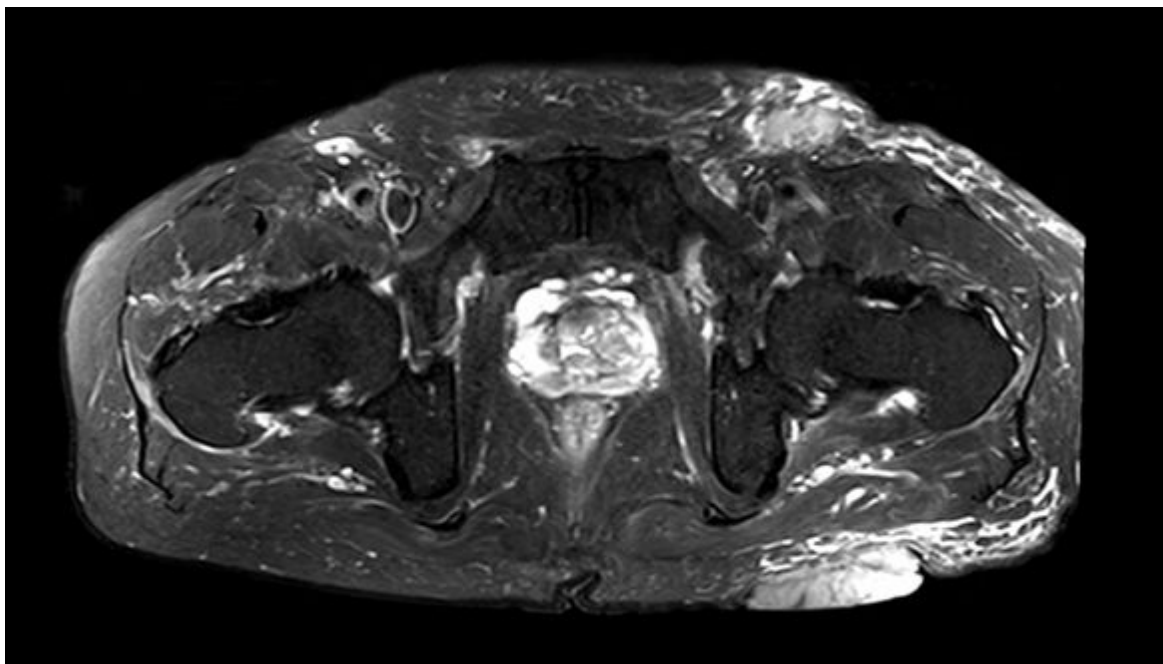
MRI showing a T2-hyperintense 5.2cm by 5.8cm by 1.9cm mass in the left gluteal region with left inguinal lymphadenopathy
